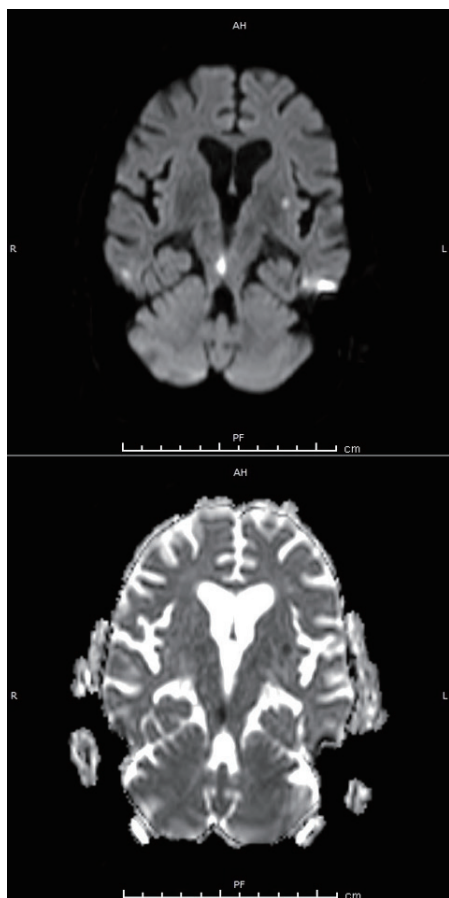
Diffusion and ADC map sequences demonstrating diffusion restricted lesions in the right caudal midbrain and the left basal ganglia. Device: 3-Tesla MRI. Slice thickness: 5 mm.
